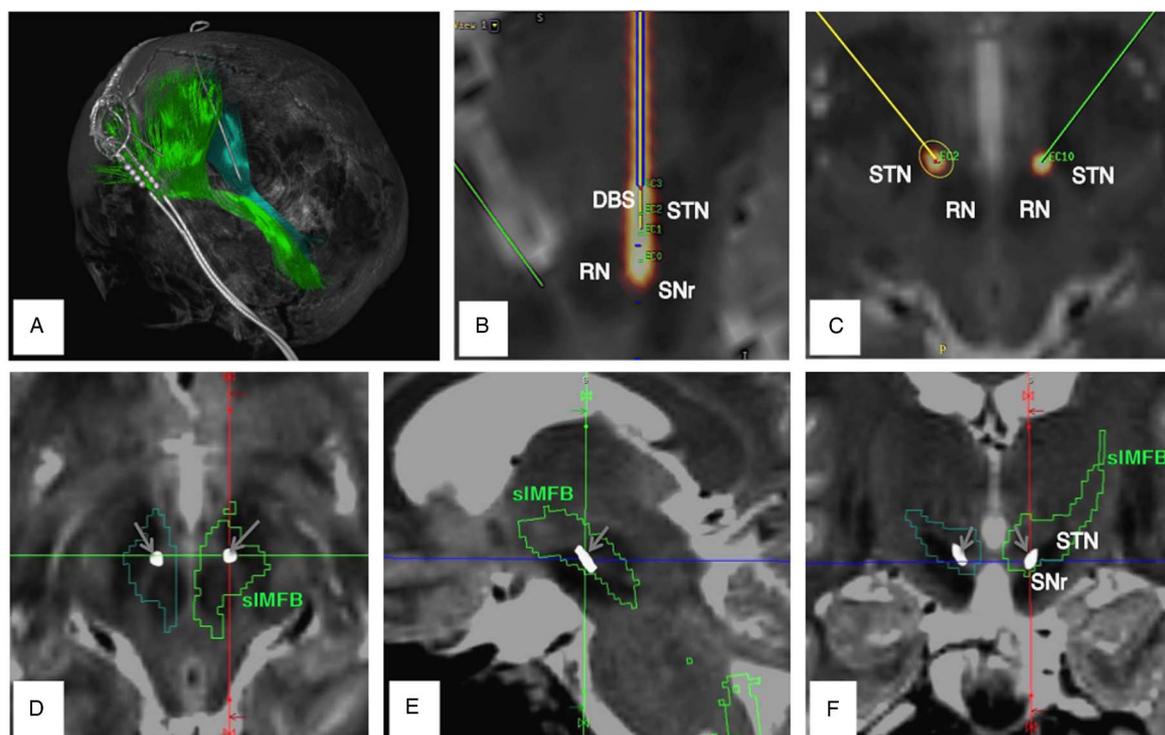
Representation of DTI tractographically assisted sIMFB DBS in patient 1. (A) Three-dimensional rendition of sIMFB (light green, left; dark green, right) with DBS electrodes (white), as seen from posterior and left. (B, C) Superimposition of computed tomography (with electrode artifact = DBS, orange) and MRI (T2). The DBS electrode is situated in a narrow corridor between the red nucleus (RN, medial) and the subthalamic nucleus (STN)/substantia nigra (SNr) region, lateral. This is the typical position. (D, E, F) Axial, sagittal, and coronal views, respectively, of electrode implantation sites with sIMFB outlines (from DTI tractography). Gray arrows indicate DBS electrode artifacts (white dots).
